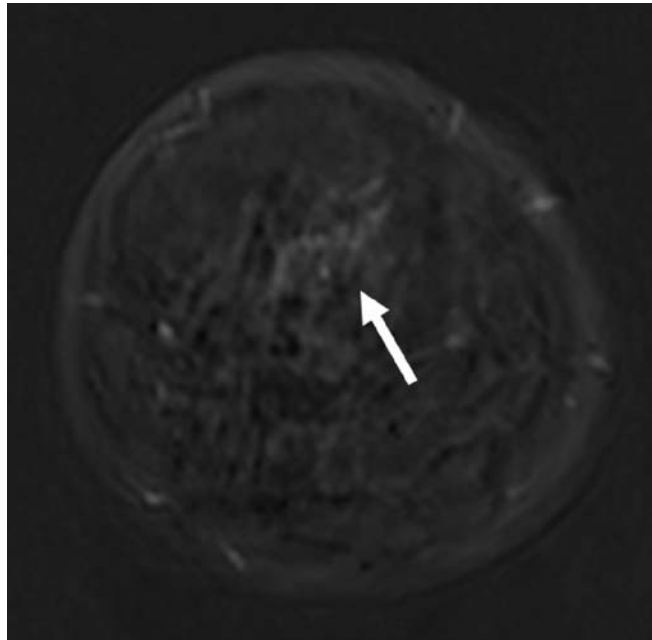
Lobular neoplasia. FLASH T1 enhanced MRI subtracted image shows mild, non-mass-like enhancement in the upper quadrants of the left breast (arrow). Sonographically-guided core-needle-biopsy demonstrated lobular neoplasia. The diagnosis was confirmed at subsequent surgical excision.
